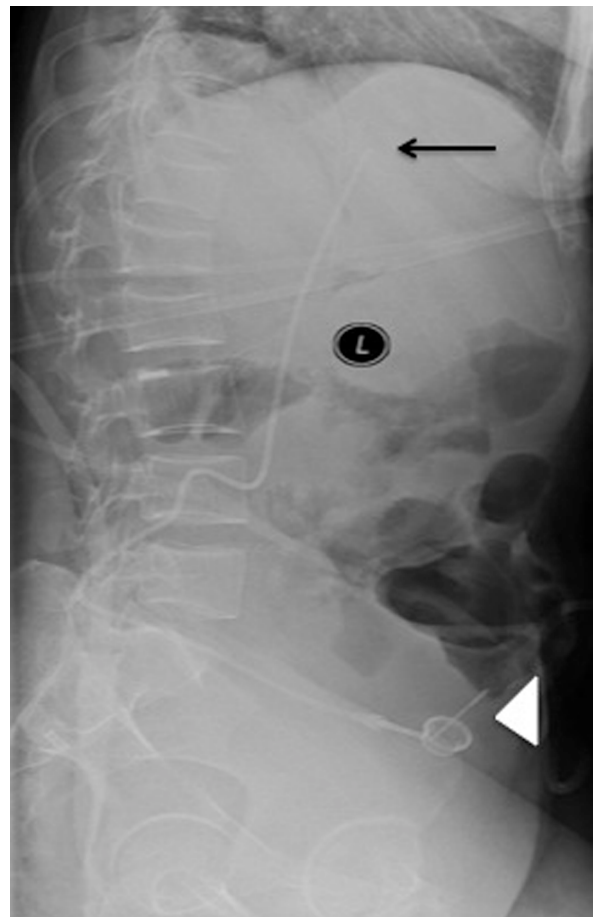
Lateral radiograph showing the translumbar chemoport. The tip of the catheter is near the cavo-atrial junction (black arrow), and the subcutaneous port is seen anterolaterally (white arrowhead).
